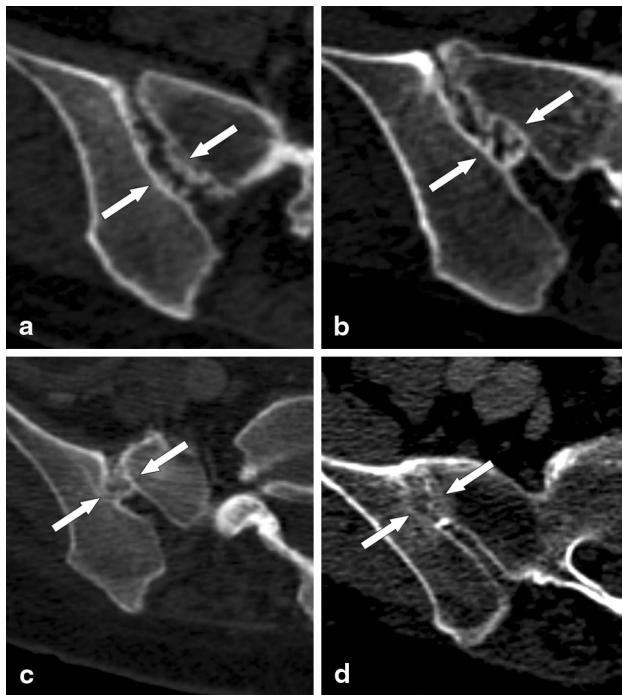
a–d Progressive ossification of the postero-superior ligamentous portion of the sacroiliac joints in four patients with primary ankylosing spondylitis. a–d Axial CT images of the right sacroiliac joint show the progressive ligamentous ossification (*arrows*) from early stages (a) to the formation of a bony bridge with partial ankylosis of the joint space (d)
